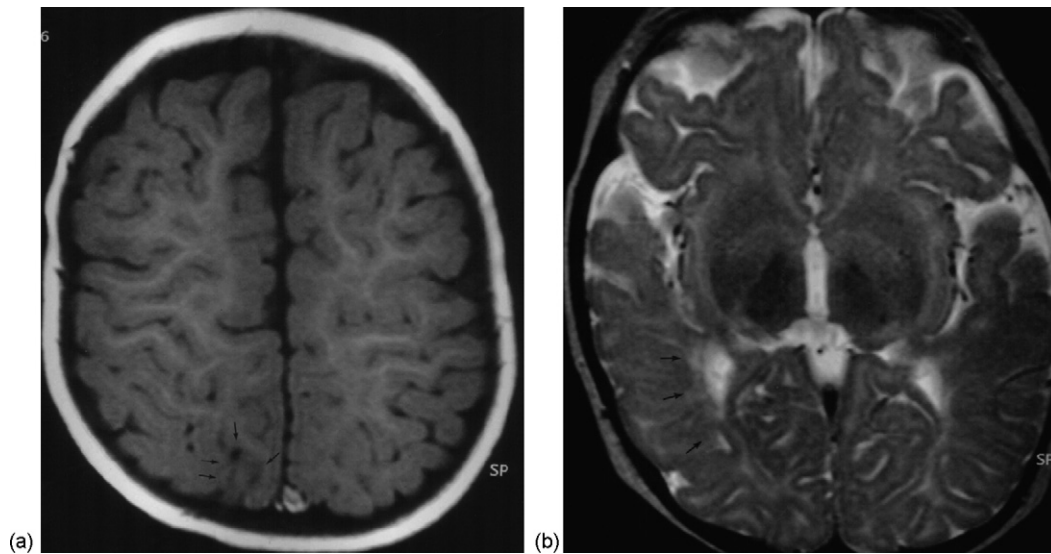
(a) T1-weighted MRI shows limited cortical necrosis occurring at the depth of the parietooccipital sulcus suggesting the presence of ulegyria (arrows). (b) T2-weighted MRI shows hyperintense appearance in the optic radiation (arrows).
